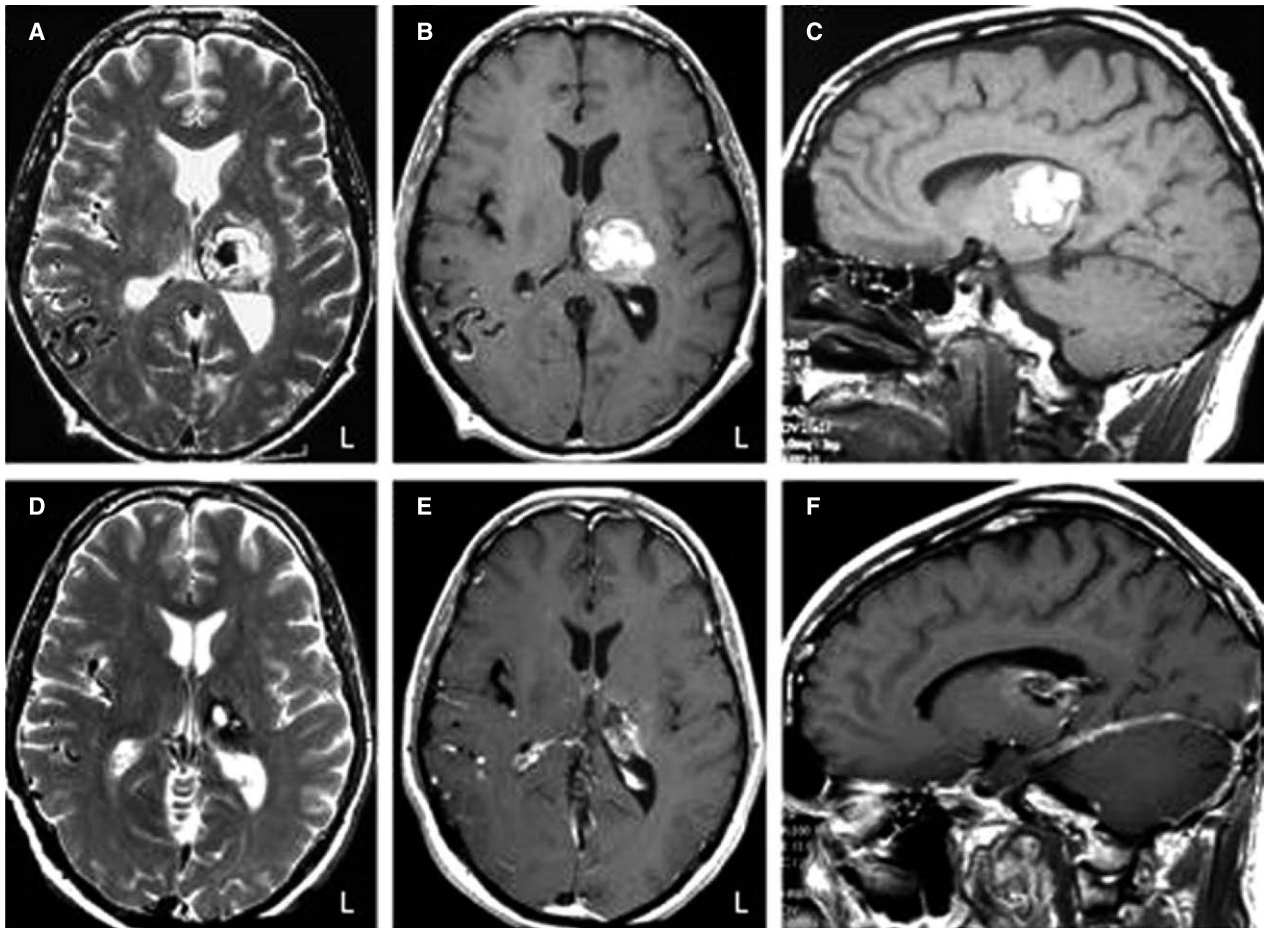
Case 4* Axial T2- (A), Gd-enhanced T1-weighted axial (B) and sagittal (C) MR images showing a cavernous malformation of 1.5-cm diameter in the left thalamus. The postoperative MRI showing the thalamic CA was surgically removed totally (D–F: T2 axial, Gd-T1 axial and Gd-T1 sagittal MRIs). Postoperatively, there was a slight improvement in sensorimotor function of the right side without any operative complication
